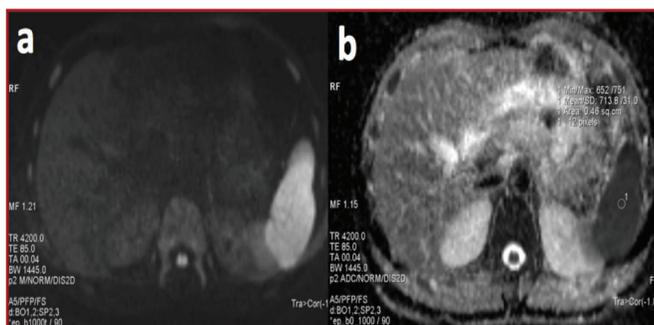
Diffusion weighted imaging (DWI) (a), and apparent diffusion coefficient (ADC) map (b) images of the spleen in a 25-year-old man with urolithiasis. The spleen shows profound restricted diffusion with hyperintense appearance on DWI and hypointense appearance on ADC map. The mean ADC value of the spleen is $0.713 \times 10^{-3} \text{mm}^2/\text{s}$.
